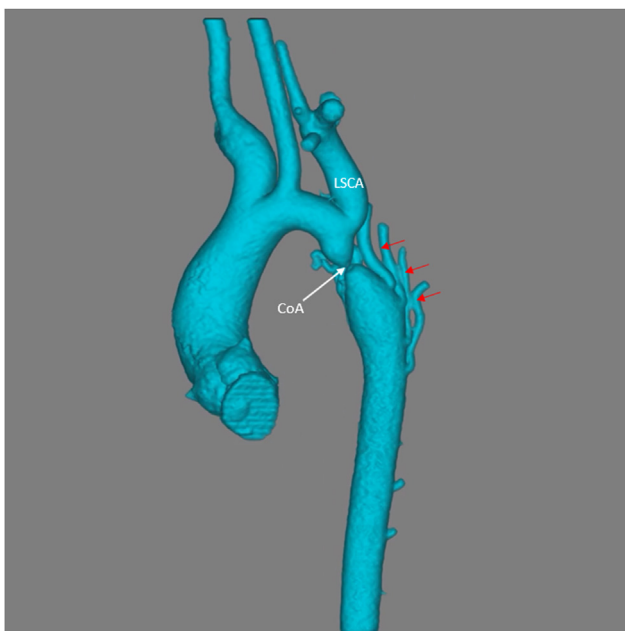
Computed tomography scan with three-dimensional volume-rendered reconstruction showing the aortic arch. There is severe CoA at the region of the aortic isthmus, distal to the left subclavian artery (LSCA) origin, along with multiple descending aortic collaterals (red arrows).
